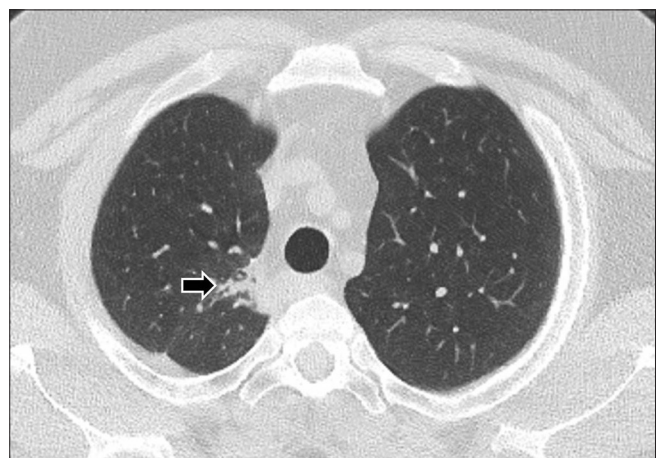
One-month follow-up chest computed tomography showing near-complete resolution of the right upper lobe abnormality and minimal residual scarring (arrow)
